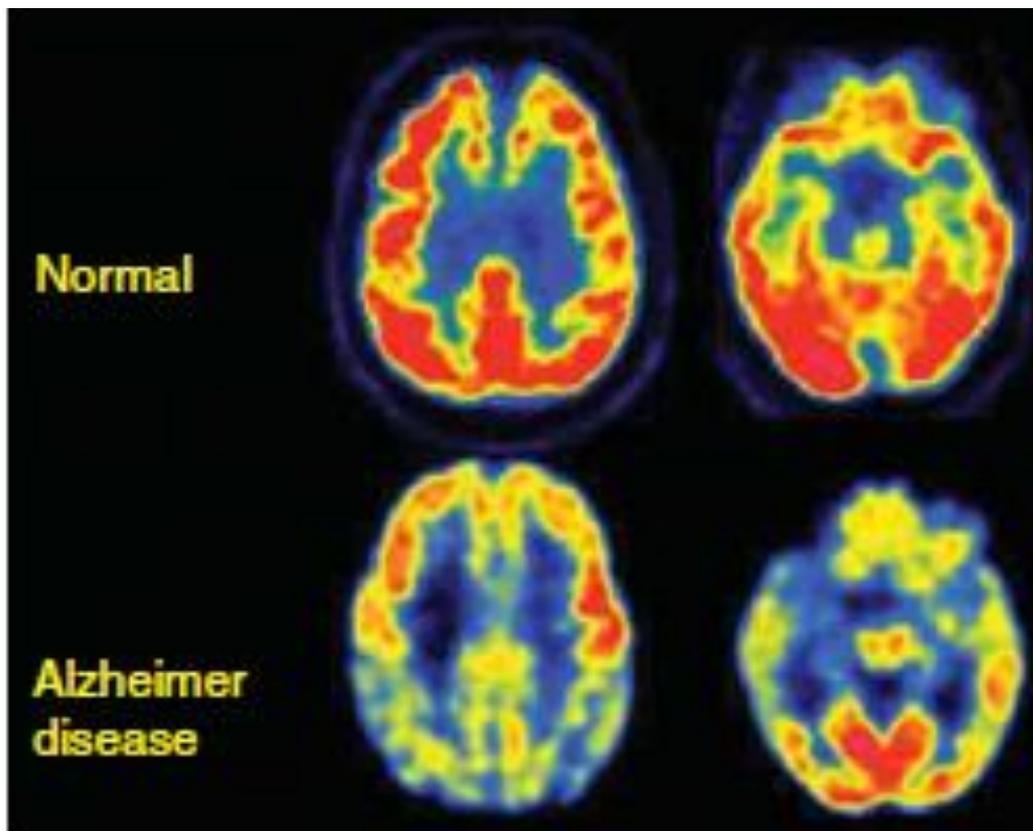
Axial FDG-PET images of a normal control and an AD patient with mild dementia demonstrate severe hypometabolism (blue and yellow cortical regions) in association and limbic cortex. (From Johnson et al. Cold Spring Harb Perspect Med 2012; 2:a006213)
